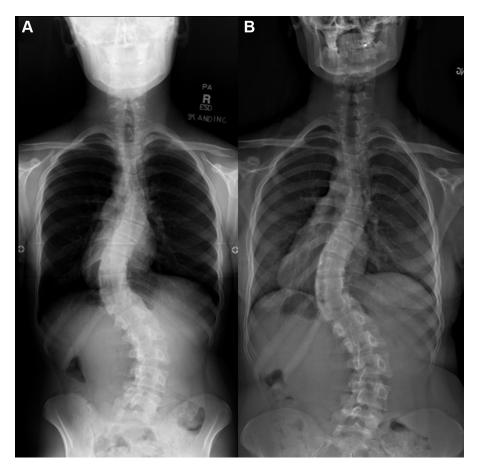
(A) Filtered computed posteroanterior radiograph of a patient with scoliosis. (B) EOS anteroposterior image of the same patient.
